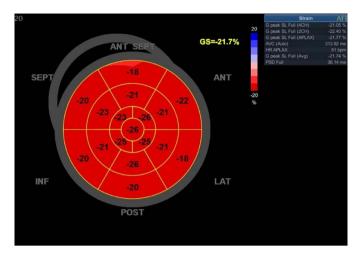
Echocardiography at discharge, GS -21.7%
